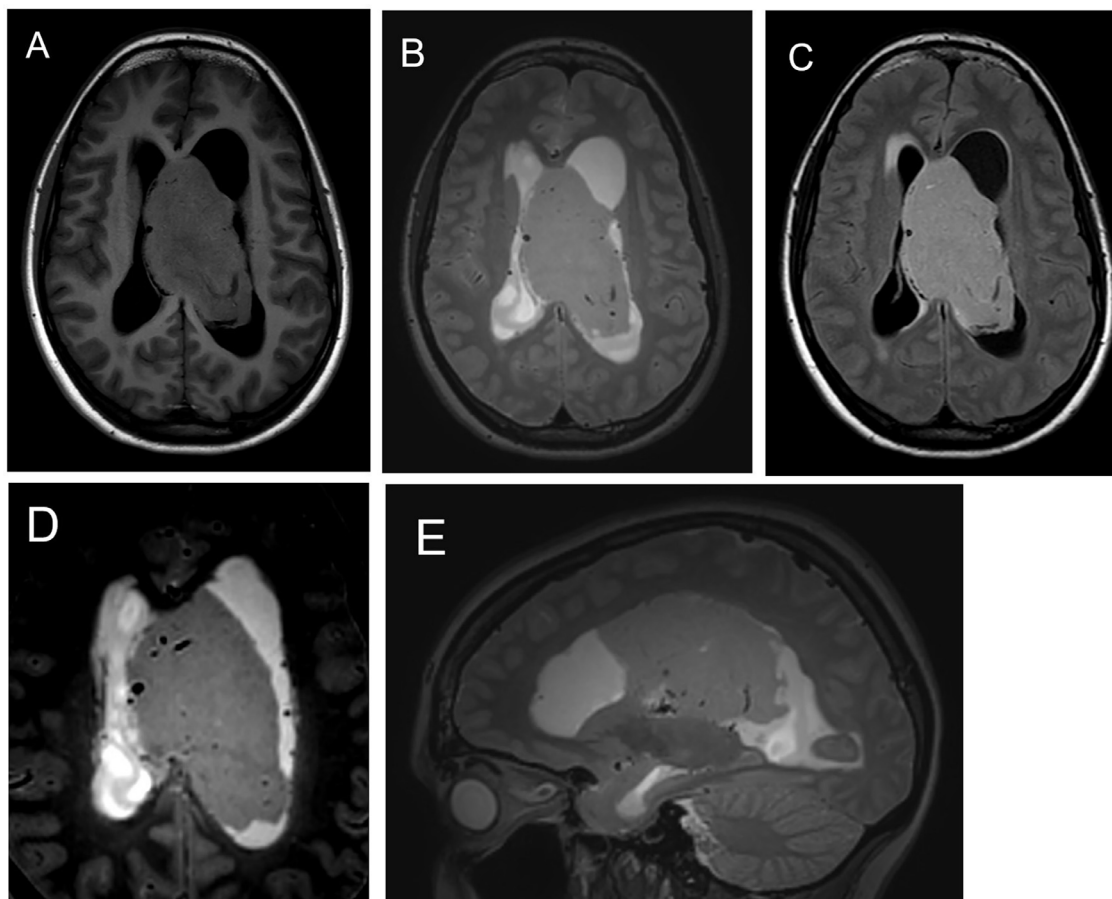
Brain MRI. (A-C) T1, T2 and FLAIR weighted images respectively: intraventricular lesion, mainly solid, isointense to gray matter on T1, slightly hyperintense on T2. Transependymal edema as hyperintensities adjacent to the frontal horns of the lateral ventricles. (D) Subtle cystic area on the periphery of the lesion (E) thin septa bridging the lesion and the wall of the ventricle.
